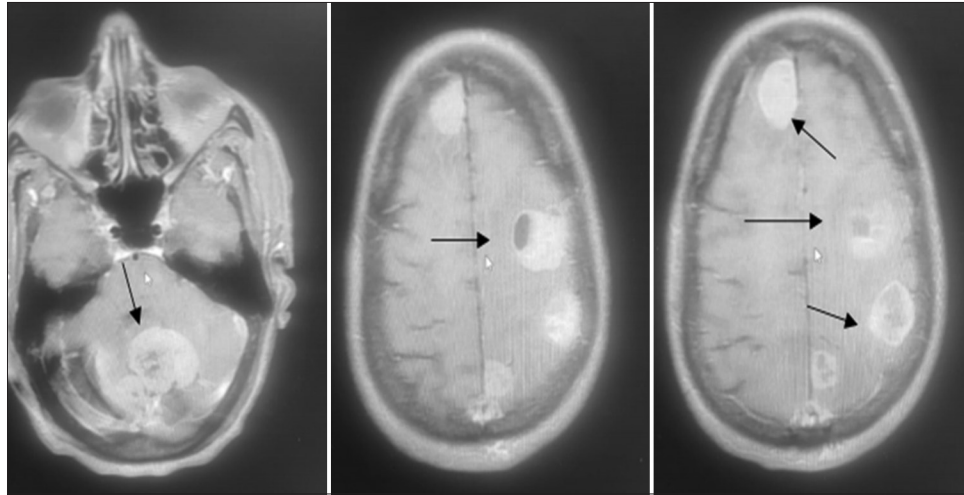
Contrast-enhanced magnetic resonance imaging brain showing metastasis in different lobes of the brain
